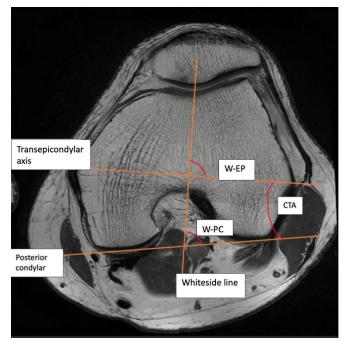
Rotational measurements used in the study. CTA; Condylar twist angle, W-EP; Whiteside-epicondylar angle, W-PC; Whiteside- posterior condylar angle WPC.
